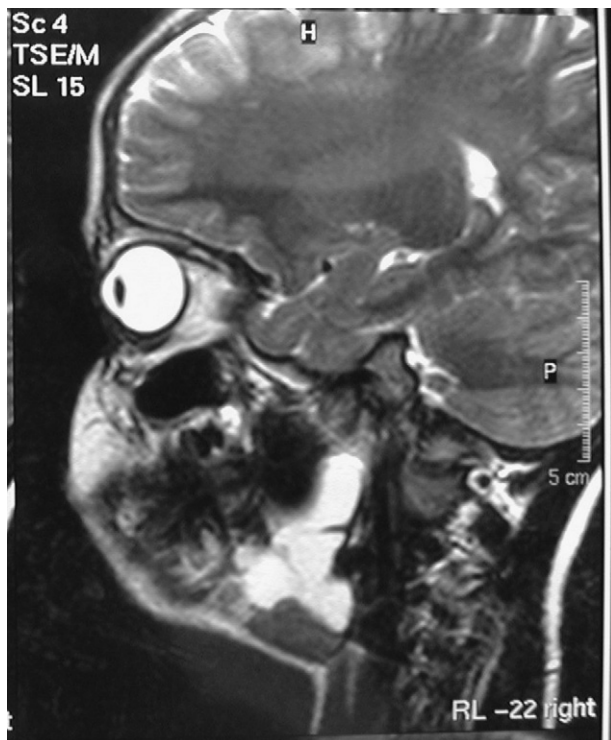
Case no. 8 MRI sagittal view of the right ranula.
